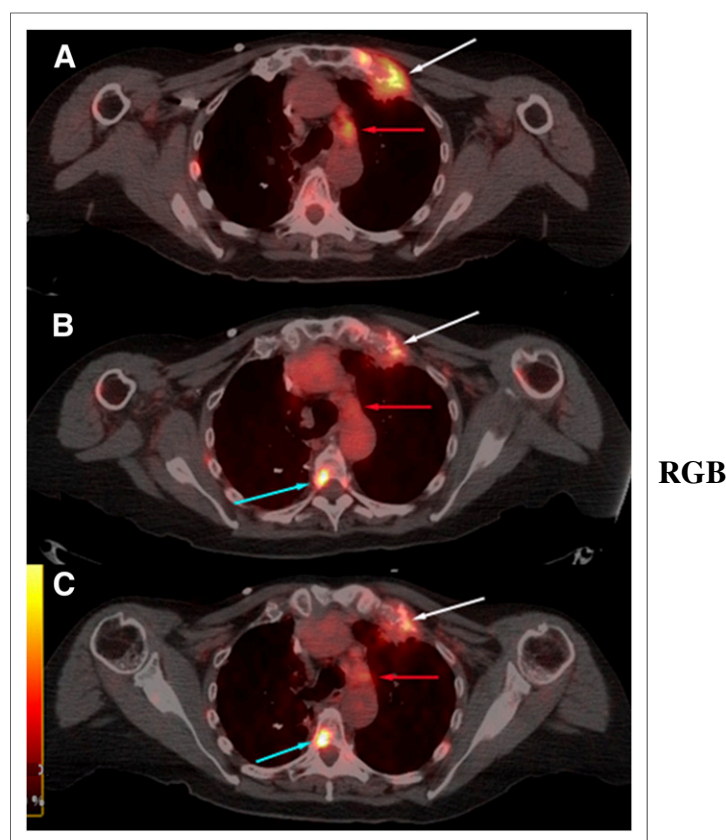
Visualization of bone and nodal metastases. Shown are transaxial PET/CT fusion images of ^{18}F -FDG (A), ^{64}Cu -DOTA-trastuzumab 23 h after injection (B), and ^{64}Cu -DOTA-trastuzumab 48 h after injection (C) from patient given 50 mg of trastuzumab. Upper intensity thresholds (white color) correspond to $\text{SUV} = 10$ g/mL. Lesion-to-non-lesion contrast improved modestly between day 1 and day 2 after ^{64}Cu -DOTA-trastuzumab injection. Lesion growing out of left first rib (white arrows) is well visualized on day 1 ^{64}Cu scan and little changed on day 2. Spinal metastasis (turquoise arrows) not seen with ^{18}F -FDG is well visualized on both day 1 and day 2 ^{64}Cu scans. On the other hand, nodal metastasis (red arrows) seen with ^{18}F -FDG is visualized only on day 2 with ^{64}Cu -DOTA-trastuzumab.
